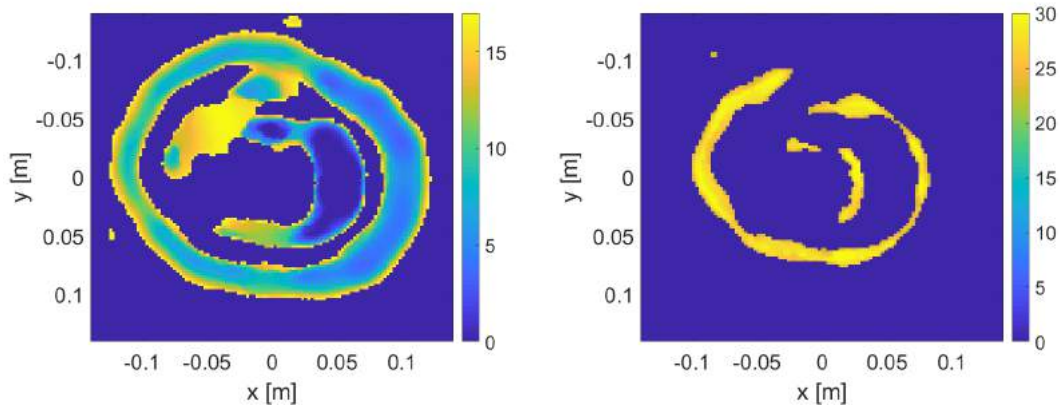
K-means clusters from the real part relative permittivity images in MRI models 1, 2, and 3 using ultrasound gel (Left = *Low-Permittivity*, Right = *High-Permittivity*).
